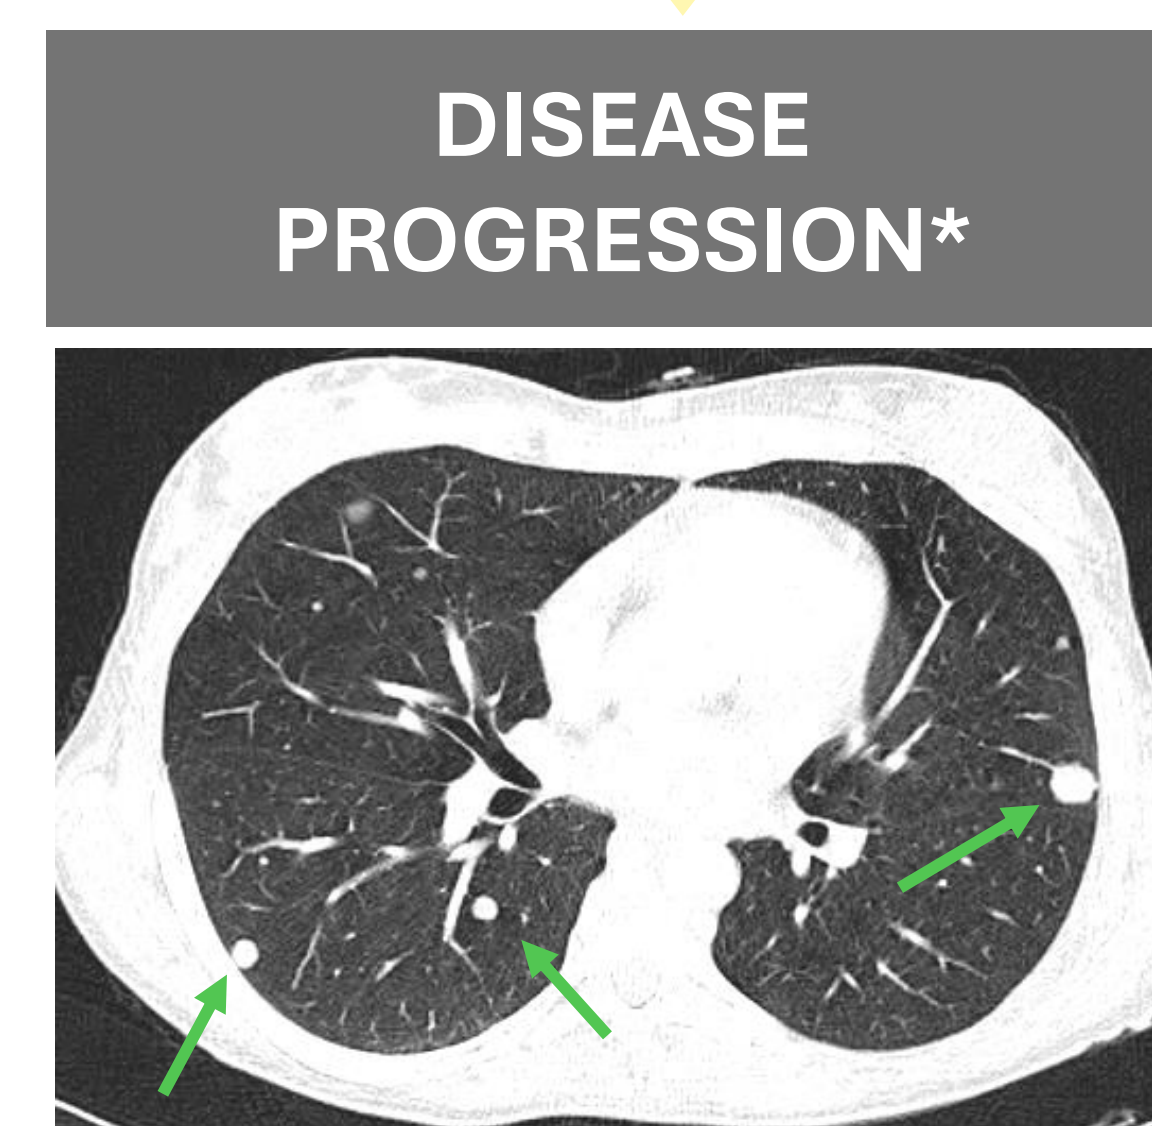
CT-scan showing multiple lung metastasis (green arrows)
